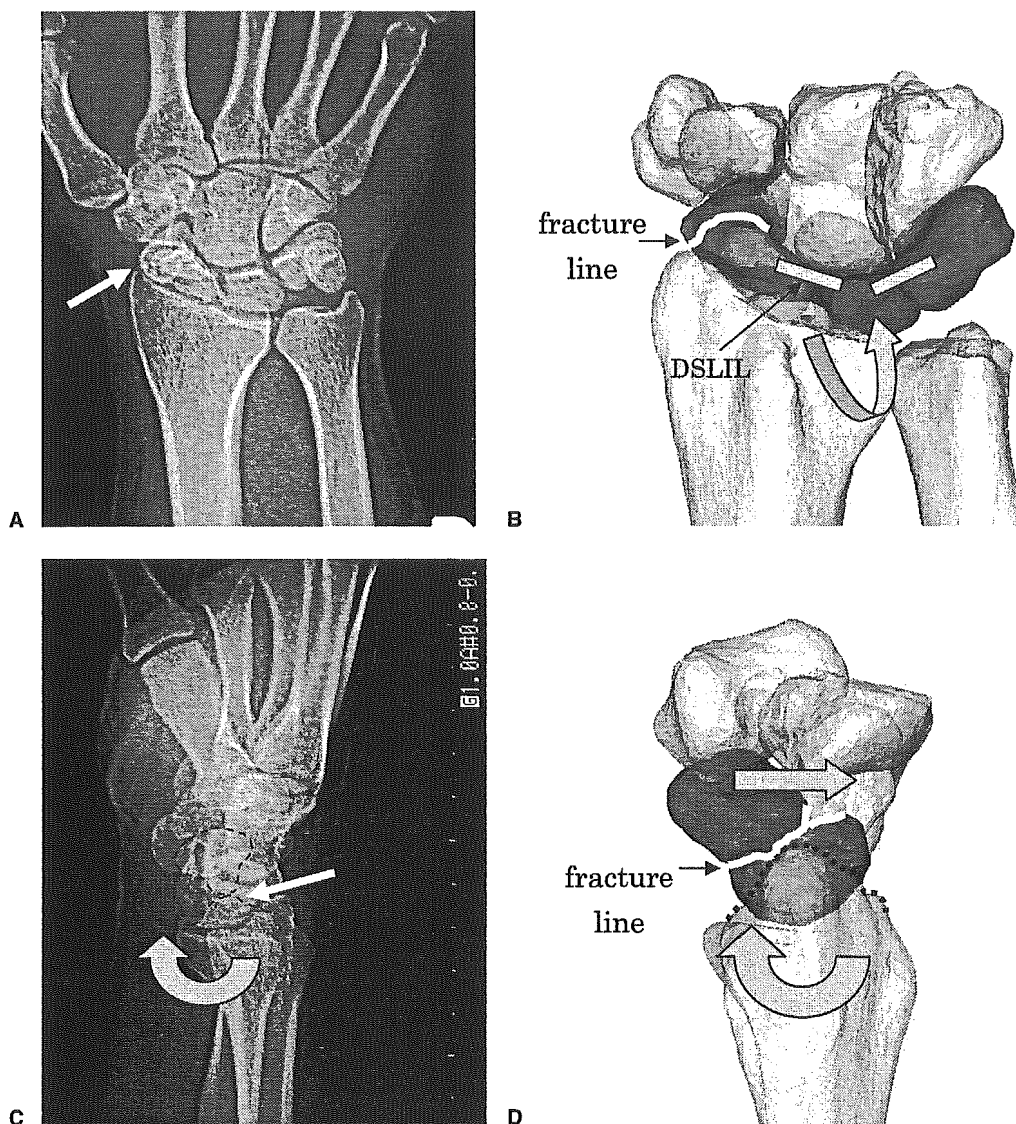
Anteroposterior view of (A) x-ray and (B) 3-dimensional surface model of scaphoid nonunion. The proximal fragment, lunate, and triquetrum rotated into extension and supination. Dogleg deformity of scaphoid nonunion and osteoarthritis of the radial styloid could be observed. (C) Lateral view of x-ray and (D) 3-dimensional surface model of scaphoid nonunion with osteoarthritis of the radial styloid. Extension of the proximal fragment and a dorsal shift of the distal fragment result in the humpback deformity in scaphoid nonunion.
